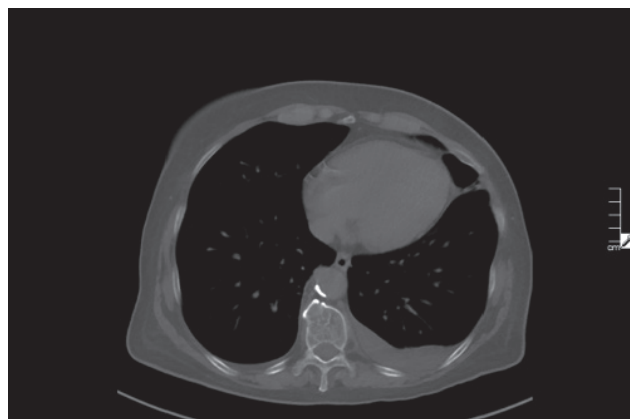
CT scan after resuscitation showing full resolution of intracardiac air
